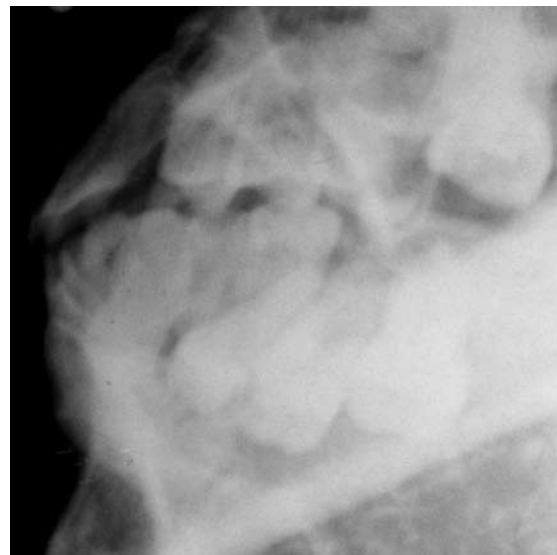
Compound odontoma. Panoramic radiograph shows multiple tooth-like structures in the left maxillary region.
